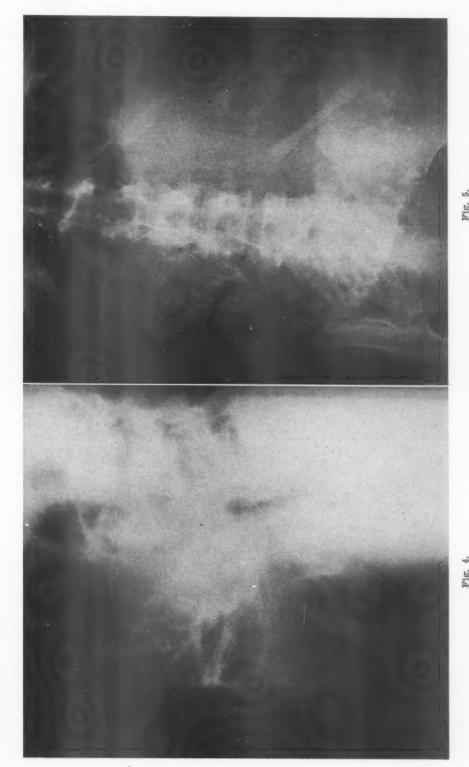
Lateral x-ray film demonstrating a fetus extrauterine with portion of the fetal cranium posterior to the anterior aspect of the mother's spine.
